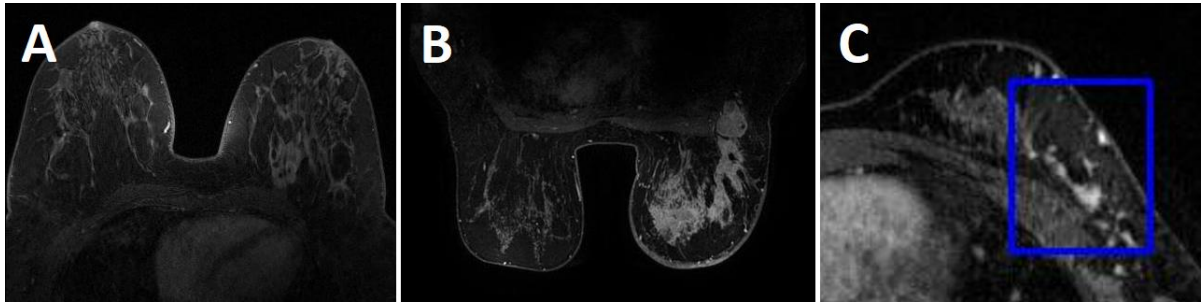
Three MRI slices with tumors from different patients. Slice C is marked without a bounding box surrounding the tumor. The top left vertex of the bounding box in slice C is clearly beyond the breast mass.
